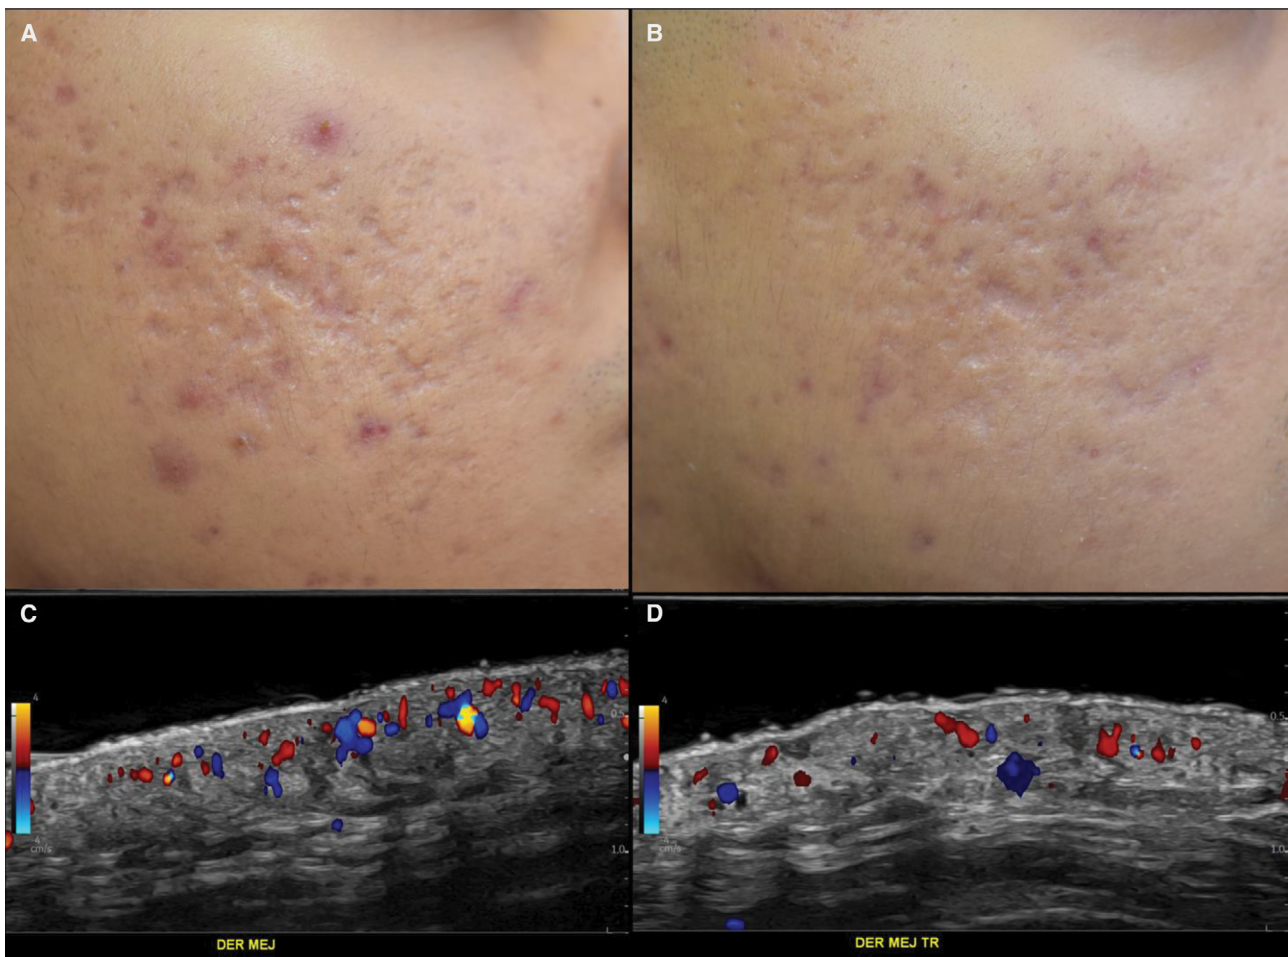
Effects on the right cheek with fractional CO2 laser. (A) Baseline clinical image; (B) Follow-up clinical image at 3 months. There is a decrease in erythema along with a clinical improvement in acne scars. Color Doppler high-frequency ultrasound at 24 MHz: baseline (C) and follow-up at 3 months (D). There is a decrease in dermal vascularity in the scar region (colors).
